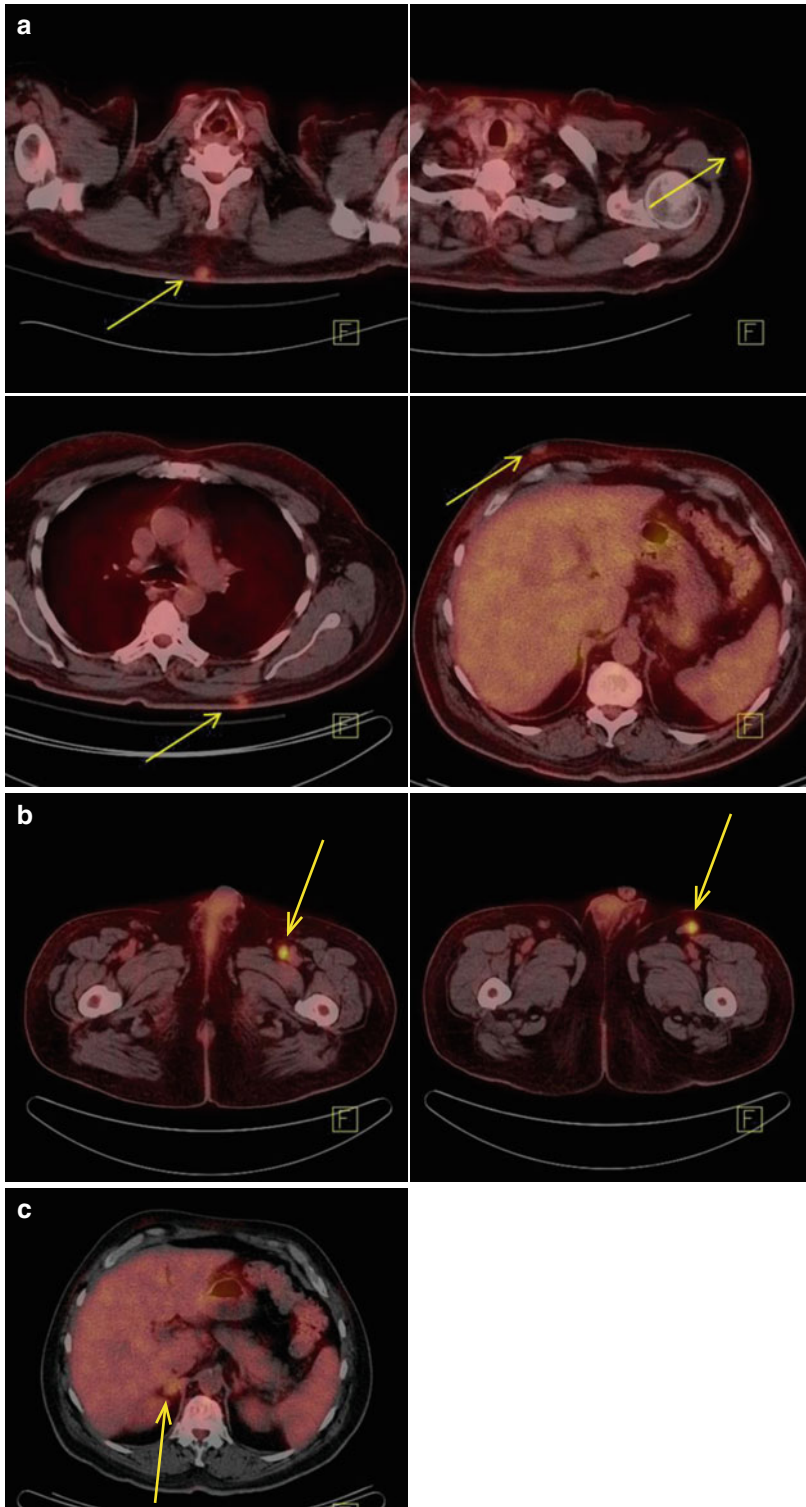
Initial staging fused PET/CT images. (a) Small subcutaneous nodules (*arrows*) at the thorax and abdomen with increased metabolic activity (SUVmax of 2.0). (b)
